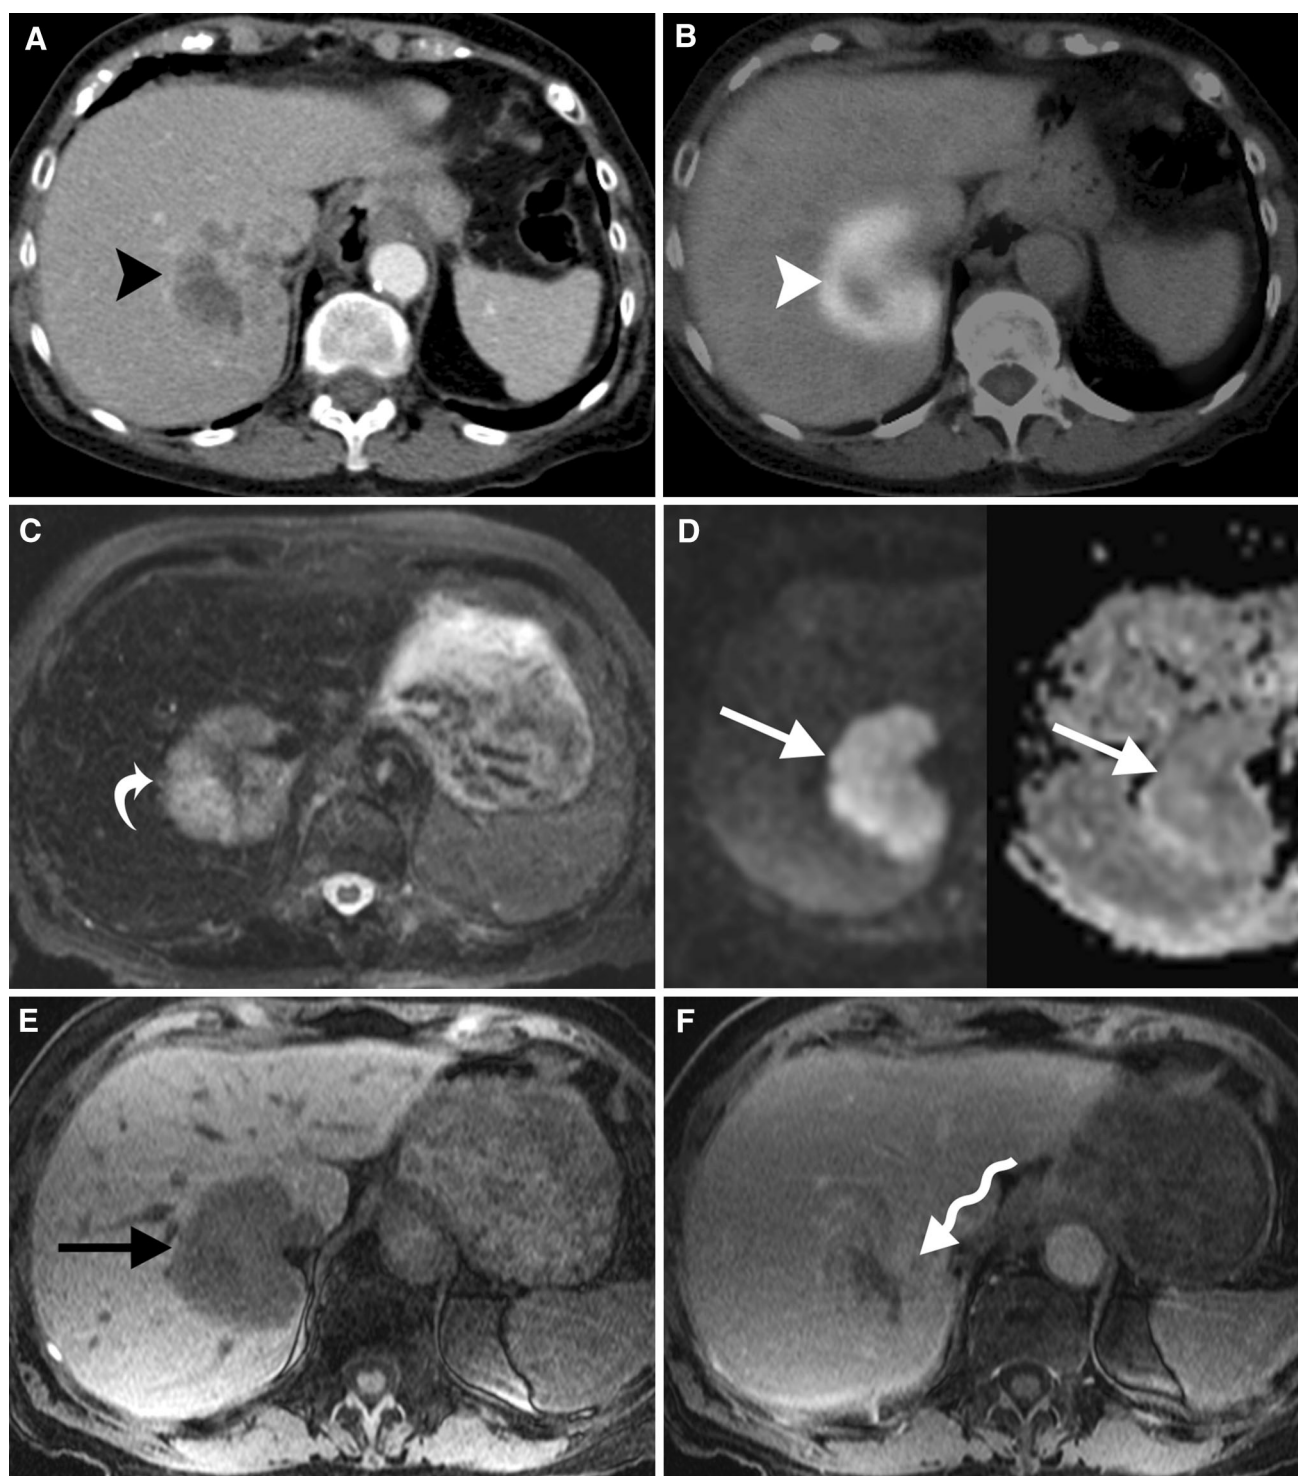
CHC in an 89-year-old noncirrhotic woman with imaging features of CC. A Axial-enhanced CT demonstrates a peripherally enhancing, centrally hypoattenuating large right hemiliver mass (*black arrowhead*). B Axial-fused PET/CT demonstrates avid FDG-uptake within the mass (*white arrowhead*). C Axial T2 fat-suppressed MRI demonstrates T2
